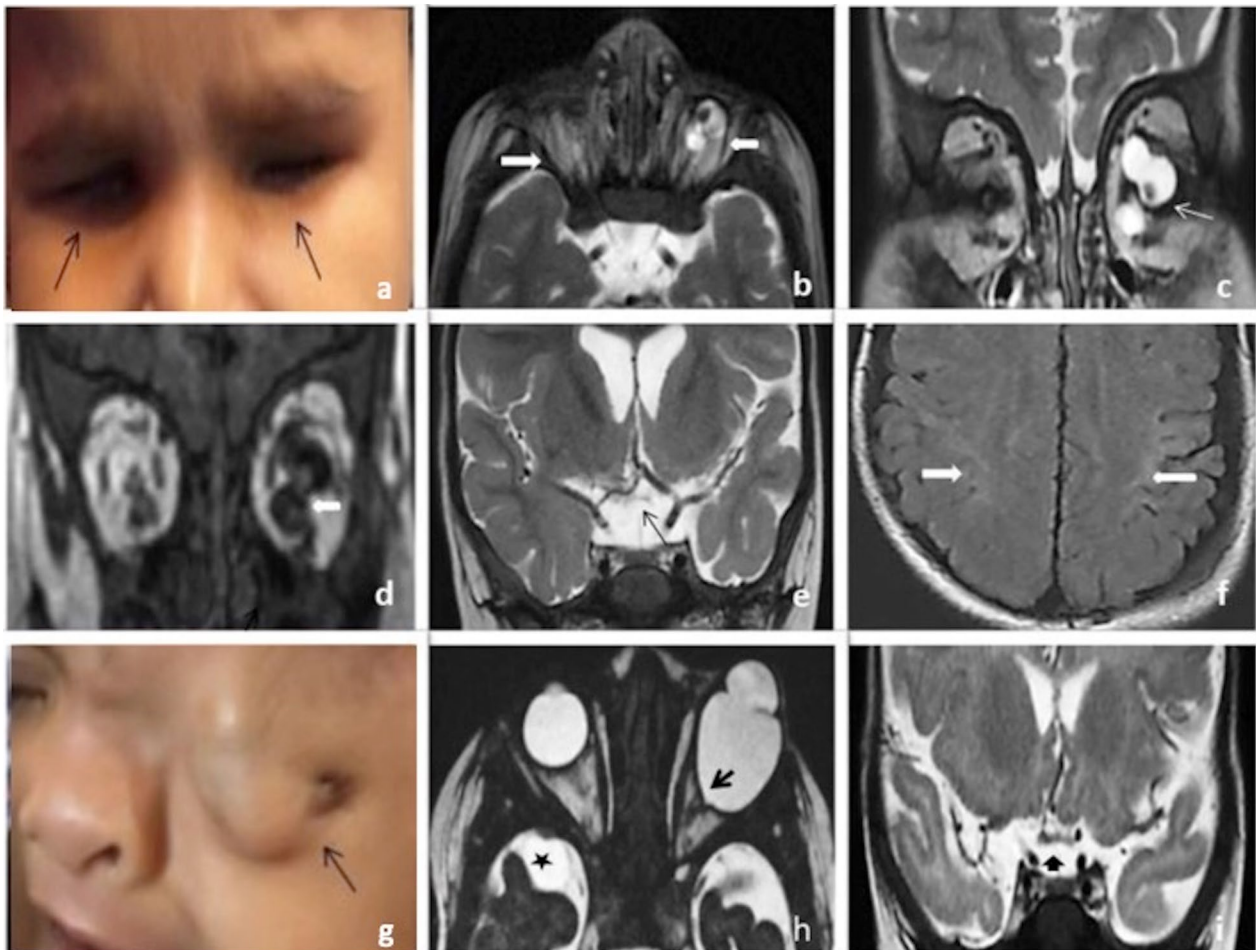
Case 1: On clinical examination, (a) right anophthalmos and left microphthalmos were seen. MRI axial T2WI (b) and coronal T2WI (c) and coronal T1WI (d) showed fibrous structure in intraconal compartment (long solid arrow in b) of right orbit, with grossly dysmorphic small dumbbell-shaped malaligned left eye globe, hypoplastic deformed intraocular lens and small inferomedially positioned fluid intensity colobomatous cyst (small arrow). Coronal T2WI (e) showed severe attenuation of right optic nerve with moderate attenuation of left optic nerve and optic chiasma (thin black arrow). Axial FLAIR image (f) showed FLAIR hyperintensity in bilateral perirolandic subcortical white matter (solid arrows). Case 2: On clinical examination, (g) left-sided cryptophthalmia (thin black arrow) with normal right eye was seen. MRI axial T2WI (h) showed enlarged left eye globe with aphakia, a defect in the iridal contour, a focal defect with beaking in the chorioretinal rim of the posterolateral aspect of globe just adjacent to the optic disk (solid black arrow) and a small right anterior temporal lobe arachnoid cyst (black star). Coronal T2WI (i) showed normal optic chiasma with minimal thinning of left optic nerve (short small solid arrow)
